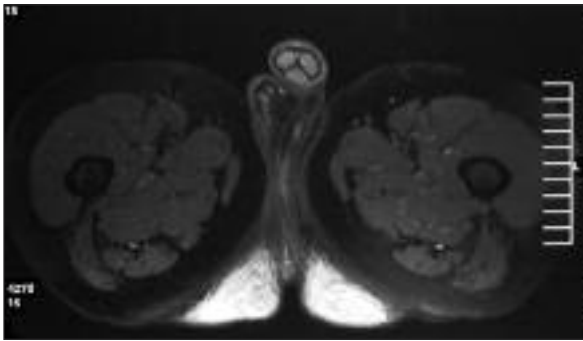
MRI of the case: T2-weighted axial image (with fat saturation) shows hyperintense masses in intergluteal region.
